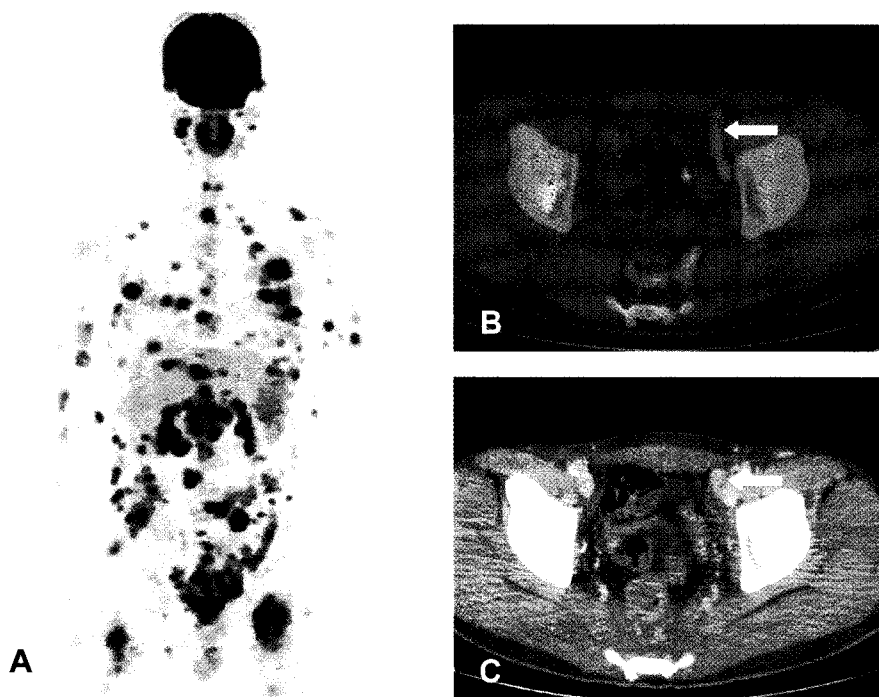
F-18 FDG PET/CT images of 24-year-old man diagnosed as an subcutaneous panniculitis-like T-cell lymphoma. (A) MIP image shows multifocal increased uptake in subcutaneous tissue and extracutaneous lesions. Selected transverse images of (B) PET/CT and (C) CT images show high F-18 FDG uptake lesions of intrapelvic lymphadenopathy (arrows) and extracutaneous lesions.
